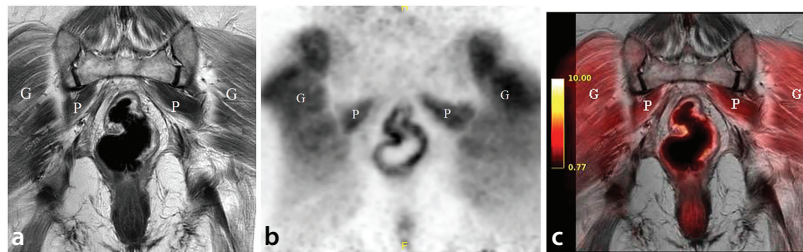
Symmetrical muscular fluorodeoxyglucose (FDG) uptake. Variable FDG uptake within the muscles throughout the body may be observed in individuals who have recently received an insulin injection, engaged in intense physical activity, or consumed a meal. In this patient, who had a history of external radiotherapy and brachytherapy due to endometrial cancer, the muscles in the pelvic region appear normal on the coronal T2-weighted image (a). The maximum intensity projection coronal positron emission tomography (PET) (b) and coronal fused PET/magnetic resonance images (MRI) (c) show diffuse and intense bilateral FDG uptake in the gluteal and piriform muscles. Whole body PET/CT imaging obtained approximately 30 minutes earlier than the PET/MRI showed no muscular uptake elsewhere in the body.
